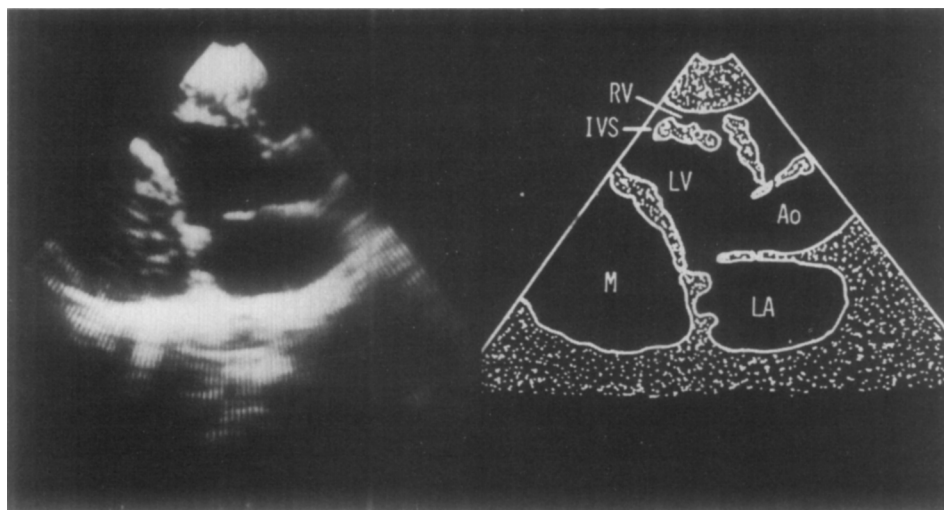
Two-dimensional echocardiogram in the parasternal long-axis view showing a large mass posterior to the left ventricle, distorting the left and right ventricles. Ao = aorta; IVS = intraventricular septum; LA = left atrium; LV = left ventricle; M = mass; RV = right ventricle.
